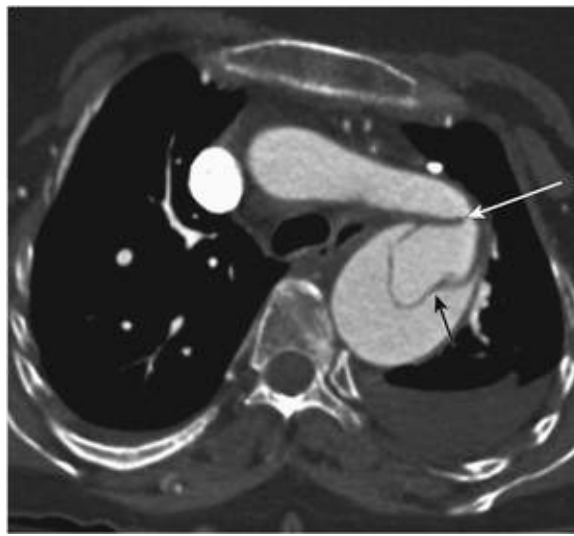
Contrast-enhanced computed tomography scan in 47-year-old woman with Turner syndrome demonstrating an elongated aortic arch, coarctation of the aorta (*white arrow*), dilated proximal descending aorta, and acute type B aortic dissection (*black arrow*).
